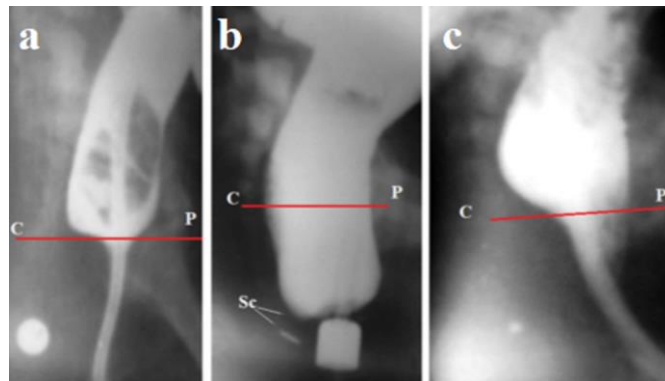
Lateral radiographs of the anorectal area of patients with visible openings of ectopic ani. (a). Anterior displacement of the anus relative to the anal dimple, to which a button was glued. Barium suspension was injected through a catheter inserted into the rectum. The anal canal located distal to the pubococcygeal line (red) is closed. It provides normal barium (stool) retention, despite the absence of the subcutaneous part of the EAS around it, since it is located above the button. (b). Upon readmission, an attempt at defecation occurred with wide opening of the anal canal. The subcutaneous part of the EAS (Sc) is located between the wall of the anal canal and the pushpin near the anal dimple. It is approximately 0.4 mm, as the true diameter of the radiopaque marker located near the ectopic anus is known to be 1.6 cm. This gap, along with the subcutaneous portion of the EAS, also contains skin and subcutaneous tissue. (c). After barium was administered to the rectum, the IAS relaxed, and the barium entered the anal
